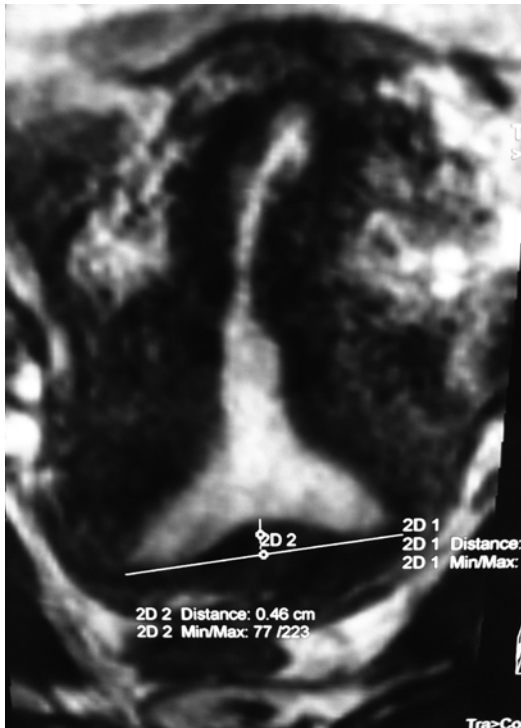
MRI image of a T-shaped uterus (ESHRE/ESGE Class U1a)
